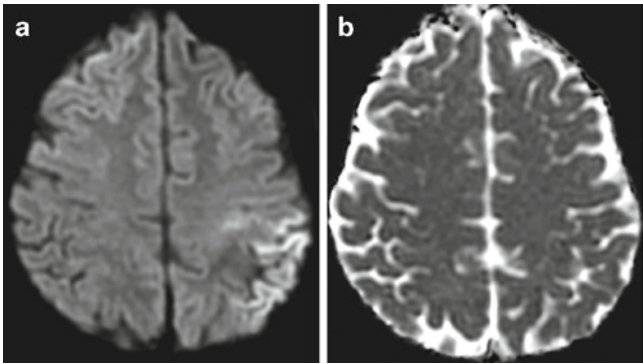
Diffusion changes associated with seizures. (a) Axial DWI and (b) ADC maps demonstrate cortical and subcortical DWI hyperintensity in the left parietal and posterior frontal lobes with minimal corresponding hyperintensity on the ADC map. The findings resolved on follow-up imaging (*not shown*)
